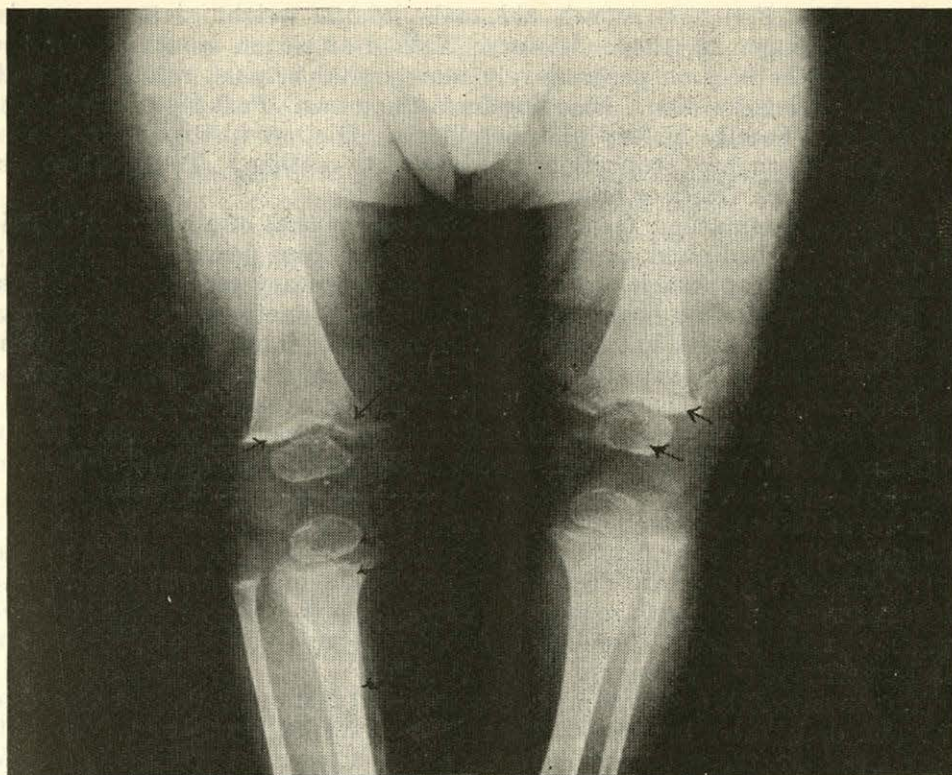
Typical X-ray appearance of scurvy (see text). Note periosteal elevation on right tibia.
